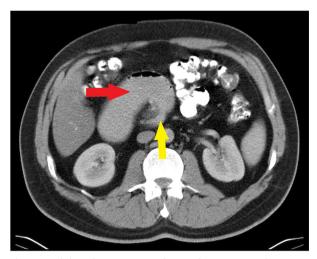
Abdo-pelvic CT scan with IV and PO contrast showing a dilated duodenal loop (red arrow) with a deflated bowel transition zone (yellow arrow).
